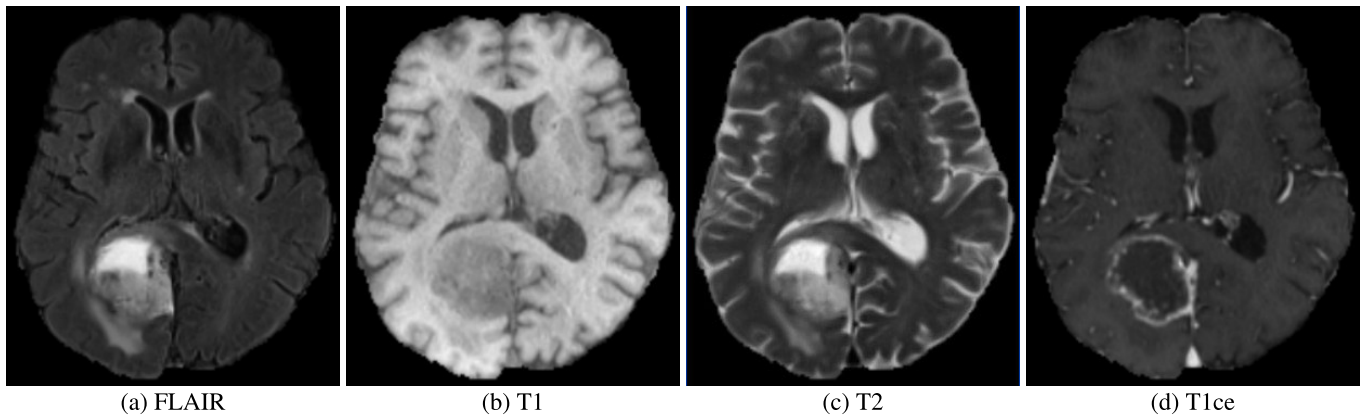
Examples of different MRI imaging modalities.
